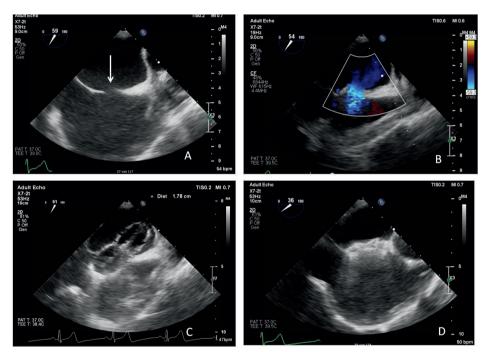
X-ray images of one of the procedures A: the wire is passed to the left atrium through the ASD. B: PVI, in this case with a cryoballoon. C: the size of the ASD is measured. D: placement of the ASD closure device.
